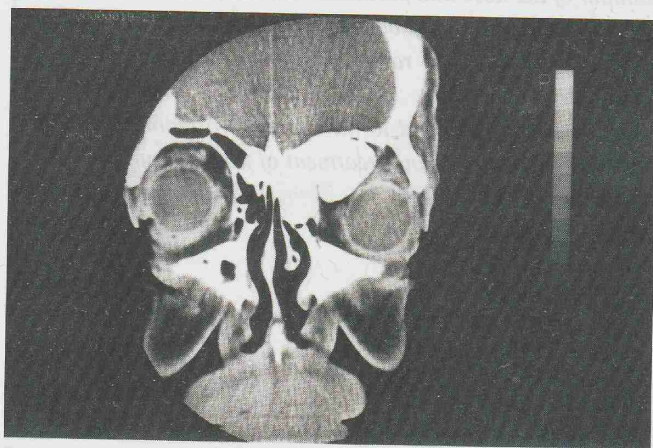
Coronal CT scan of same patient.
